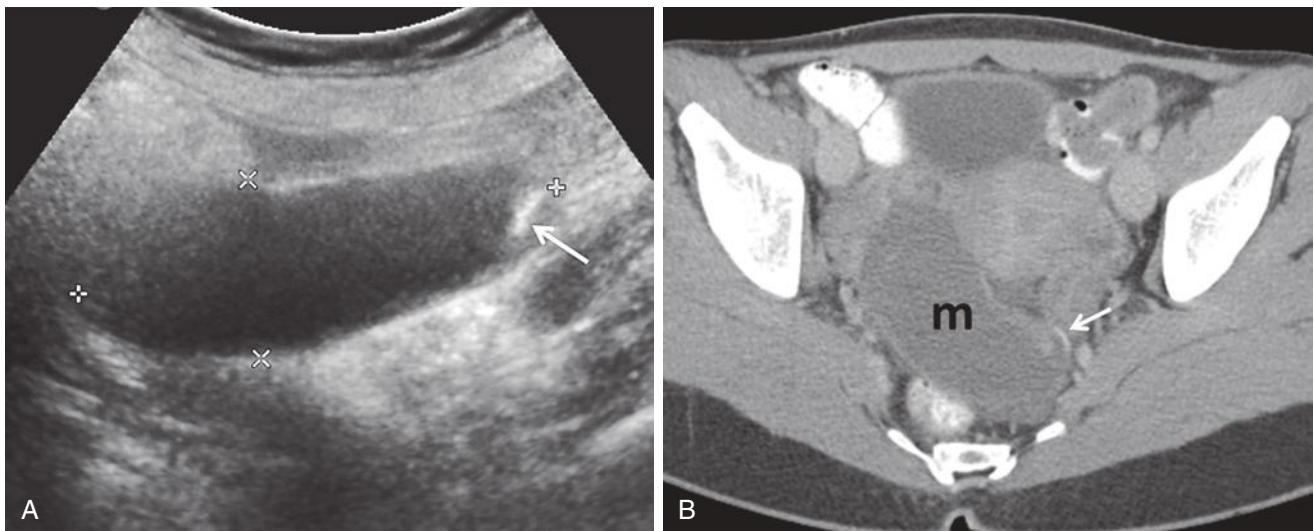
Mucocele of the appendix. A, Transabdominal ultrasound image of right lower quadrant demonstrates a markedly dilated, blind-ending tubular structure (*calipers*) with mural calcification at the tip (*arrow*). B, Contrast-enhanced axial computed tomography confirms that the mucocele (*m*) originates from the base of the cecum and has mural calcification (*arrow*).
